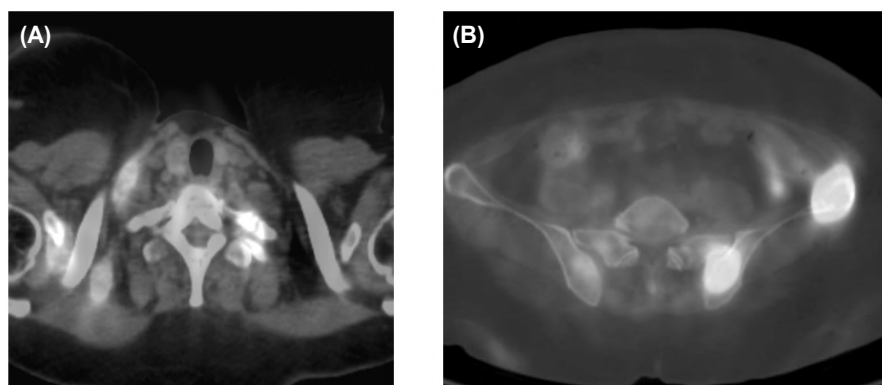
PET-CT revealed multiple metastatic nodal and osseous lesions.
